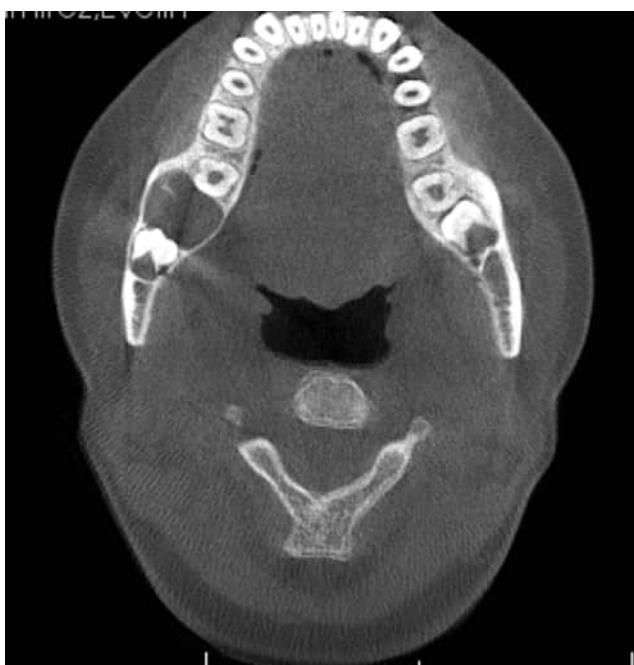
CBCT, axial view (Fig. 5.26). Note the moderate expansion buccal-lingual.
